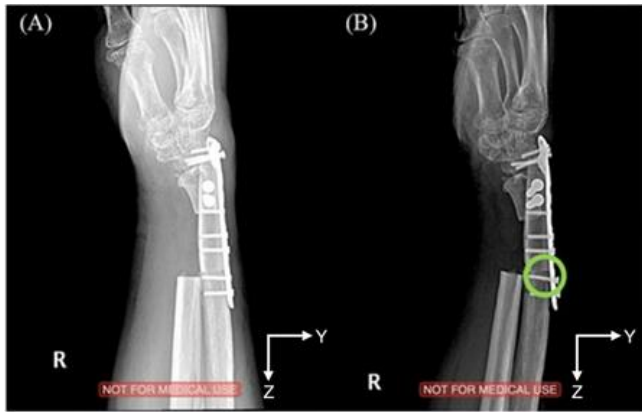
(A) The radiography image after performing the surgery with the en bloc resection method on the right distal radius of a 60-year-old man. (B) The radiograph image of the deformed bone at the area of vascularized graft and a screw loosened from its position at the second bottom of the distal radius locking plate (shown marked using the green circle). The Y-axis represents the frontal axis and the pull-out axis (dorsal).
